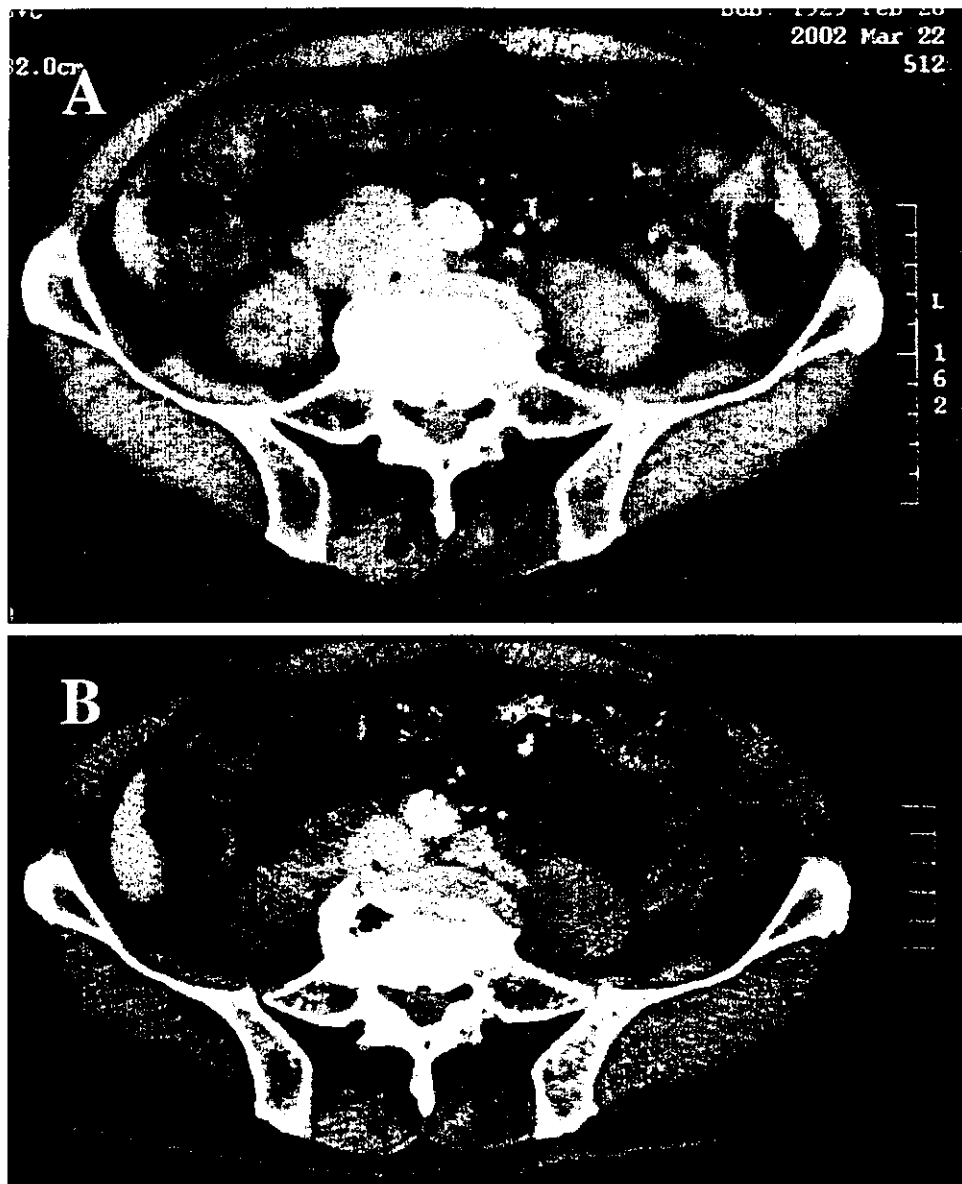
CT images of Case 12. A: Para-aortic lymph node metastasis (arrow) was detected by a CT scan at the beginning of combination therapy. B: A repeat CT scan after 8 months with the combination therapy showed a 44% decrease in the size of lymph node metastasis (arrow).
